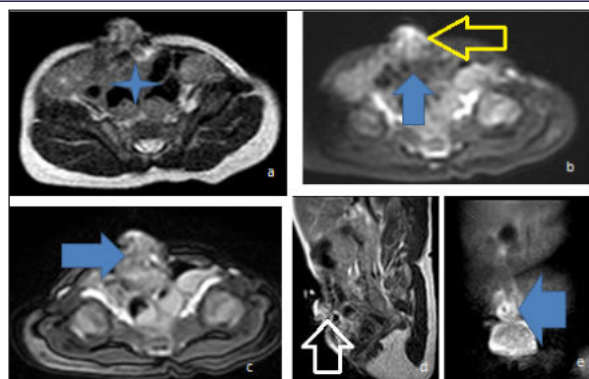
MRI abdomen of the neonate. a) axial T2WI shows prolapsing gut contents (blue star). b) T2WI with fat suppressed sequence shows hyperintense protruding VIT (yellow arrow) and gut loops within abdomen (blue arrow). c) Fast Field Echo (FFE) axial section shows structures in line with the outer flower like mass (horizontal blue arrow). d) T2WI sagittal section shows the wall defect and out pouching contents (upwards white arrow). e) T2WI coronal section shows hyperintense rounded lesion depicting PVIT (horizontal blue arrow).
